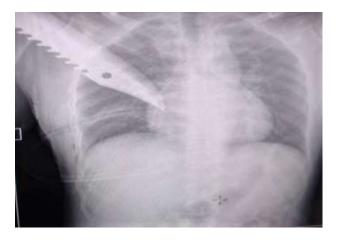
Chest radiograph (post ICD insertion) picture showing dagger and intercostals drain *in situ*.
